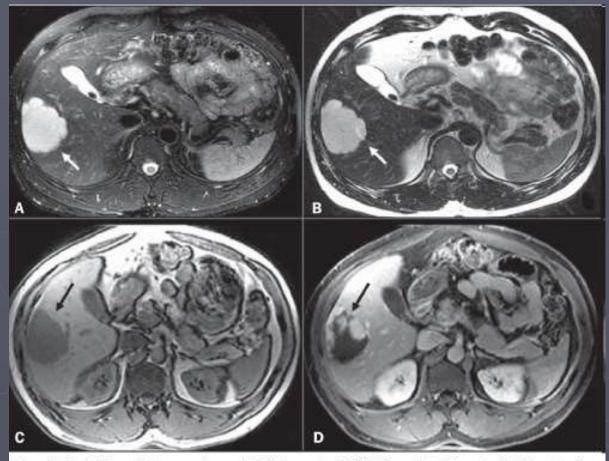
Typical hepatic hemangioma at MRI (arrows). A: FSE T2-weighted image with fat-saturation, i scho time = 90 ms; B: FSE T2-weighted image without fat saturation, TE 180 ms; C: precontrast, GRE f1-weighted image; D: portal phase, contrast-enhanced GRE T1-weighted image. Note the remarkable, bersistent hyperintense signal on the T2-weighted image and peripheral, globular uptake in the post-p contrast, portal phase.
